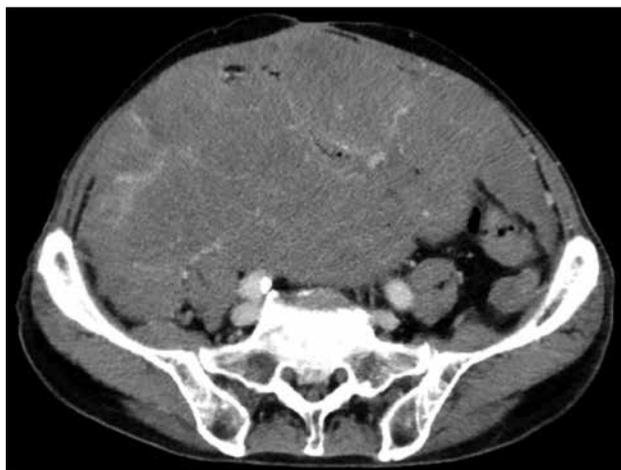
Small bowel gastrointestinal stromal tumour in an 84-year-old man with small bowel partial resection. Follow-up computed tomography scan 11 months after surgery showing multiple solid peritoneal masses, suggestive of metastases.
